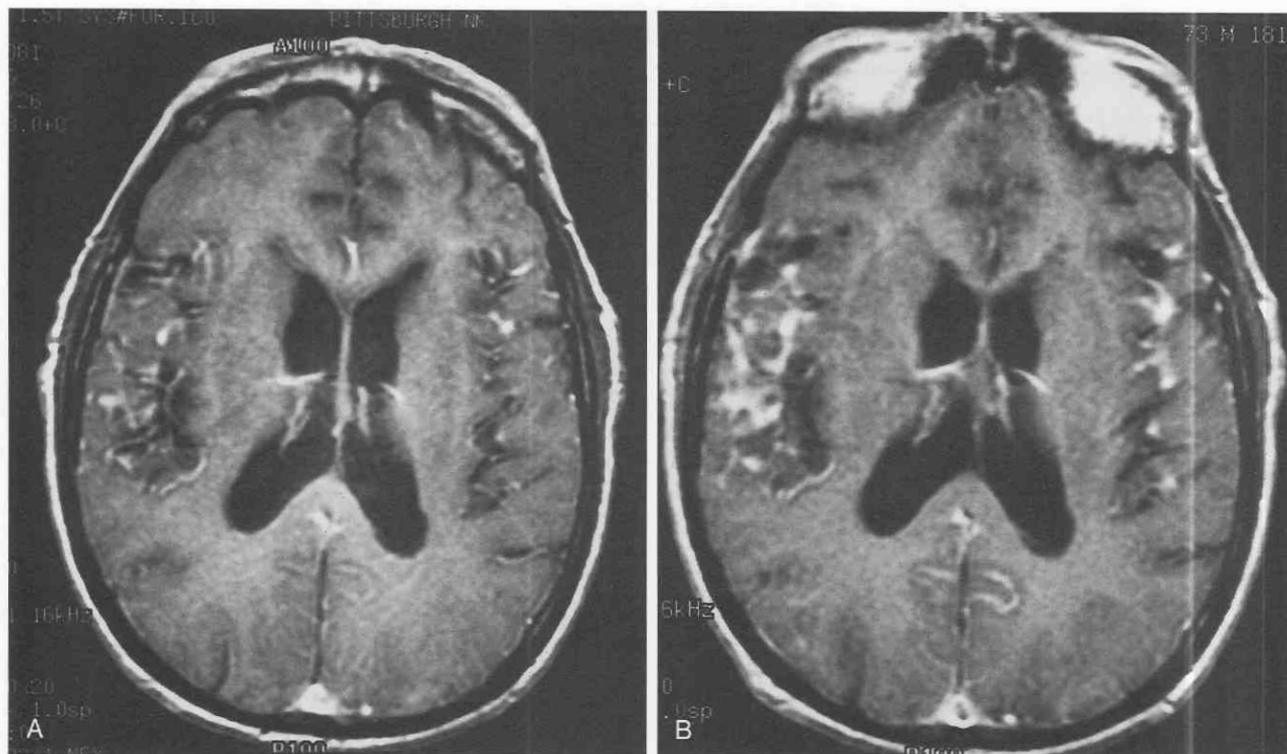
Effect of contrast dose on meningeal enhancement. Axial T1-weighted images obtained after administration of 0.1 mmol/kg (A) and 0.2 mmol/kg (B) doses of gadolinium show increased enhancement in a pia/subarachnoid space pattern at the higher dose in this patient with carcinomatosis of the meninges from gastric carcinoma.
